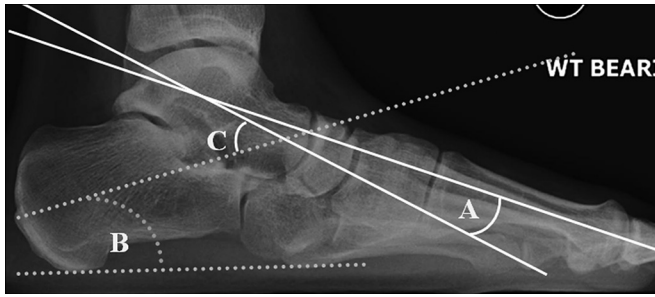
Weightbearing lateral radiograph of the foot demonstrating (A) talo-first metatarsal angle, (B) calcaneal pitch, and (C) talocalcaneal angle.
